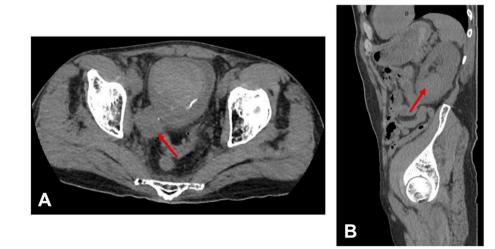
CT abdomen pelvis without IV contrast showing A) urinary bladder mass in axial view and B) left inferior pole renal mass in sagittal view.
